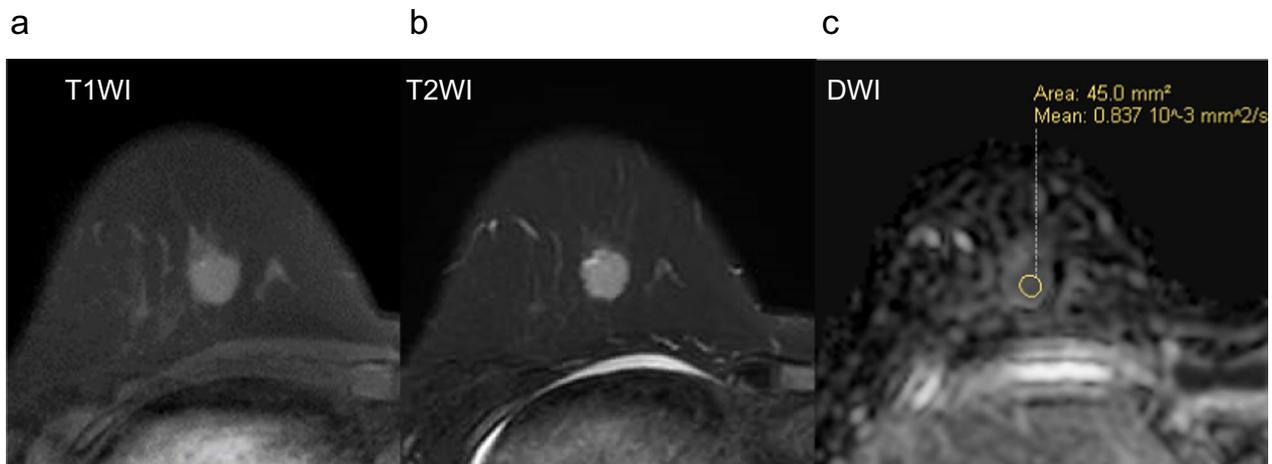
Magnetic resonance imaging (MRI) showed the tumor detected as equal signal intensity (SI) on T1-weighted images (WI) (A), and high SI on T2-WI (B). C This tumor showed mild diffusion restriction on diffusion-weighted imaging (DWI) (ADC value $0.837 \times 10^{-3} \text{ mm}^2/\text{sec}$)
